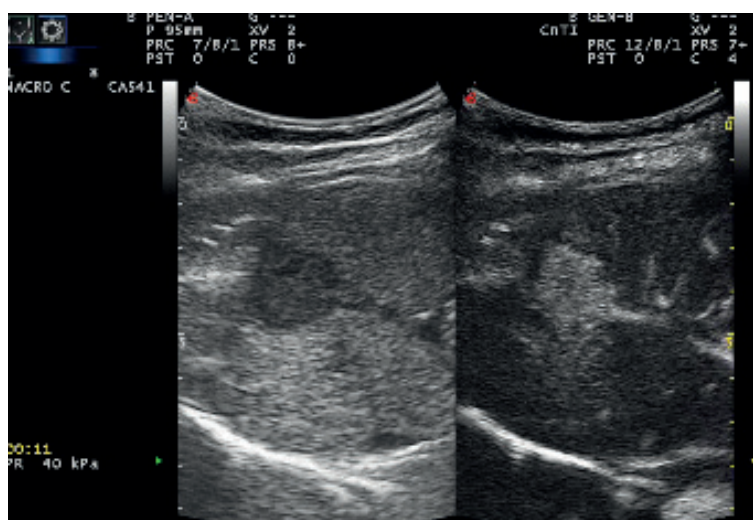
Ultrasound evaluation. Contrast-enhanced ultrasound image describing a nodular 18 mm lesion characterized by uniform early-phase enhancement.
